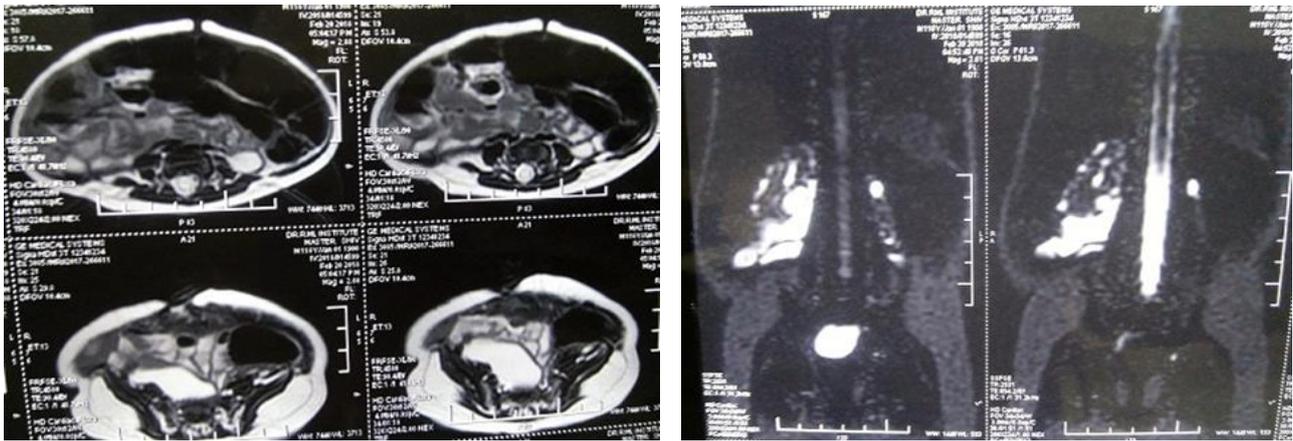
Magnetic resonance imaging (MRI) showing bilateral megaureters with cystic dilatation of kidneys, thin abdominal wall and superior vesical fissure.
